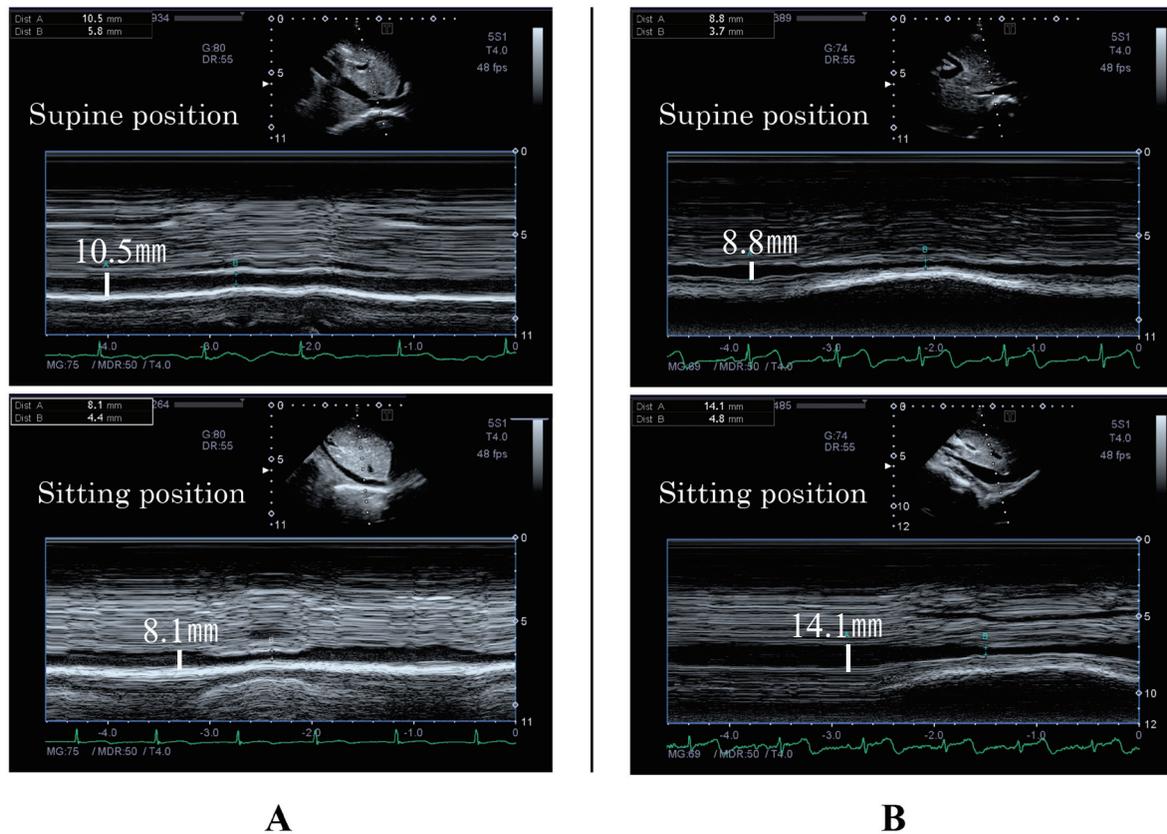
The changes in the maximum IVC diameter with postural changes on representative echocardiograms in POTS patients.
